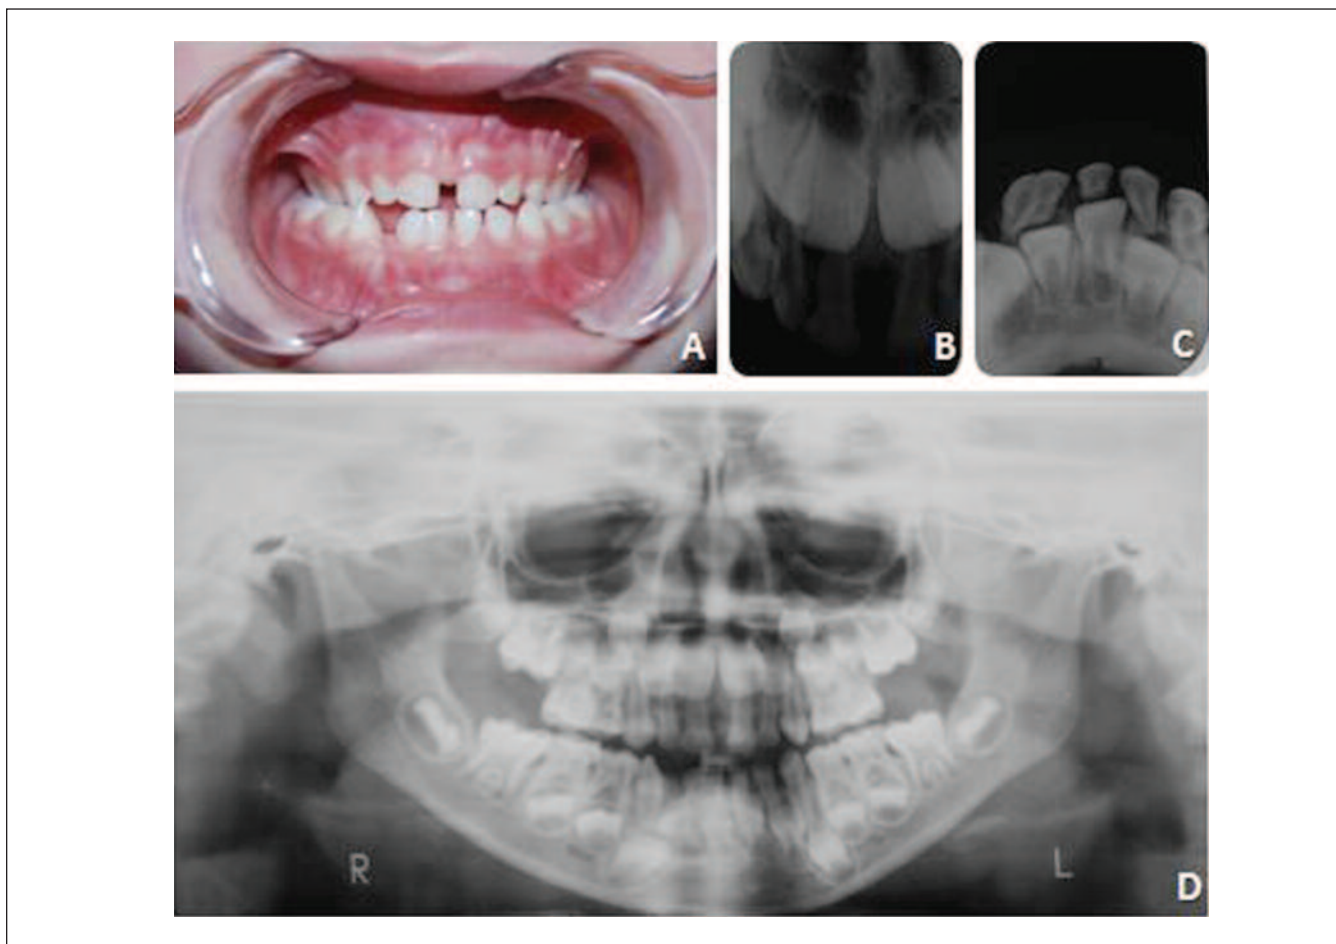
A: Primary teeth of the child at age four. B, C: Upper and lower periapical radiographs of the anterior region. D: Panoramic radiography showing normal primary and permanent dentition.
